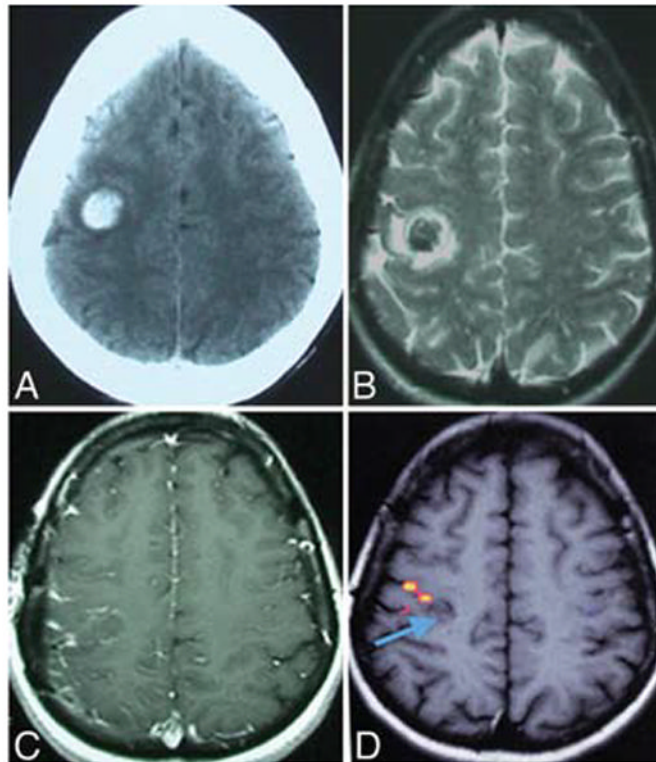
Representative CT scan and T2-weighted (B), T1-weighted (C), and functional (D) MR images obtained in a patient who presented with acute onset of left arm and hand paresis. The CT examination (A) revealed focal hemorrhage in the rolandic region. T2-weighted images (B) revealed a hemorrhagic lesion with surrounding edema, consistent with acute hemorrhage. The T1-weighted images (C) did not clearly clarify the location of sensorimotor structures in relation to the lesion. These were easily outlined by functional MR imaging (D), with zones of activation in response to left hand movement shown in *red-orange*. The region of functional activation on fMR imaging corresponded to reversal of somatosensory median nerve evoked sensory potential recording on the cortical surface, confirming the location of the rolandic sulcus. A more posterior sulcus was chosen for image-guided transsulcal microsurgical resection of the lesion (*blue arrow*), which proved to be a CCM, and the resection was accomplished without worsening in motor or sensory function.
